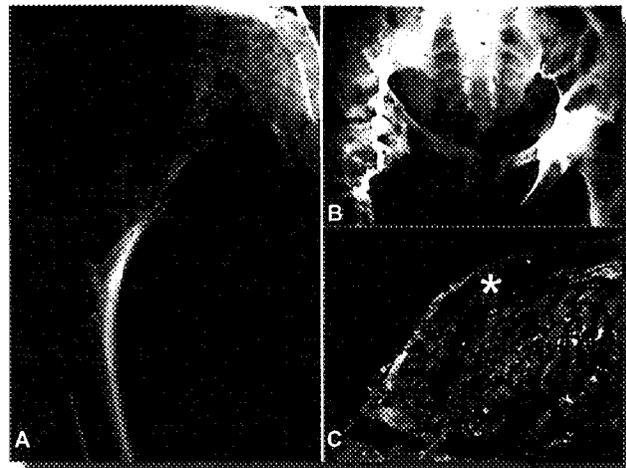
A-B. Radiographic images from FD patients showing a growing lesion of the femoral neck (A) and a case with extensive involvement of right femur and pelvic bones (B). C Post-mortem examination in a case of MAS with severe FD of craniofacial bones. The thickness of the calvaria is markedly increased due to the deposition of intramedullary FD bone (asterisk)
